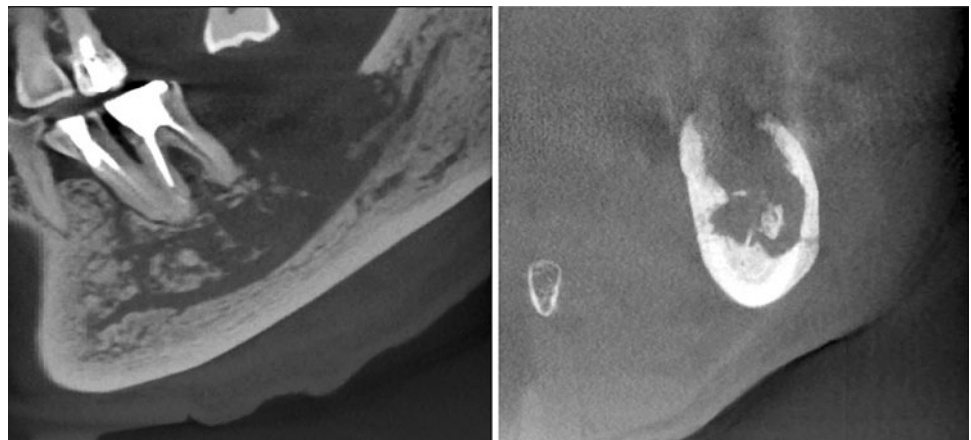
Cone beam computed tomography of BRONJ. Discernible bucco-lingual cortical bone destruction can be seen, suggesting an advanced stage of illness
